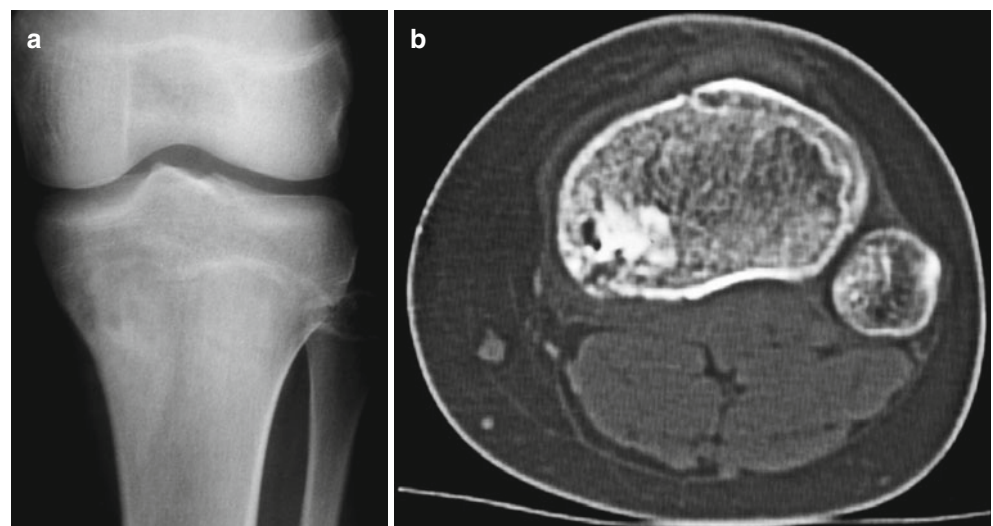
Some osteosarcomas may appear indolent on the roentgenograms (a) and CT imaging (b)
